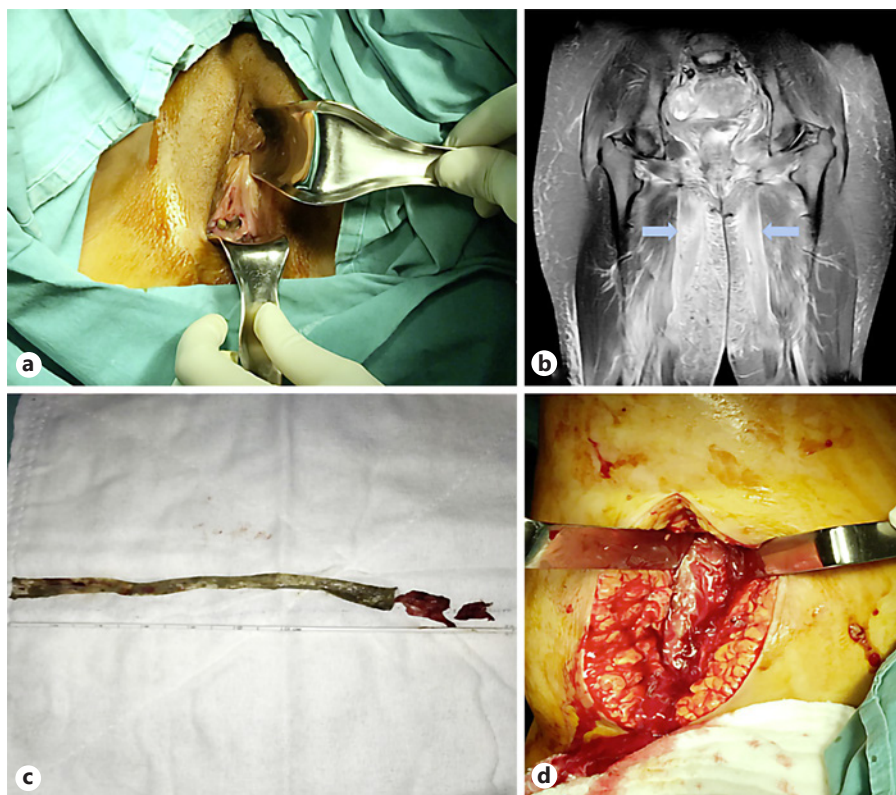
a Inspection of vagina shows dehiscence of periurethral incision and exposed mesh material. b Magnetic resonance imaging shows bilateral fasciitis originating from the obturator fossa and extending to the popliteal area (blue arrows). c, d Mesh was removed, and the obturator and thigh abscesses were incised and drained.
